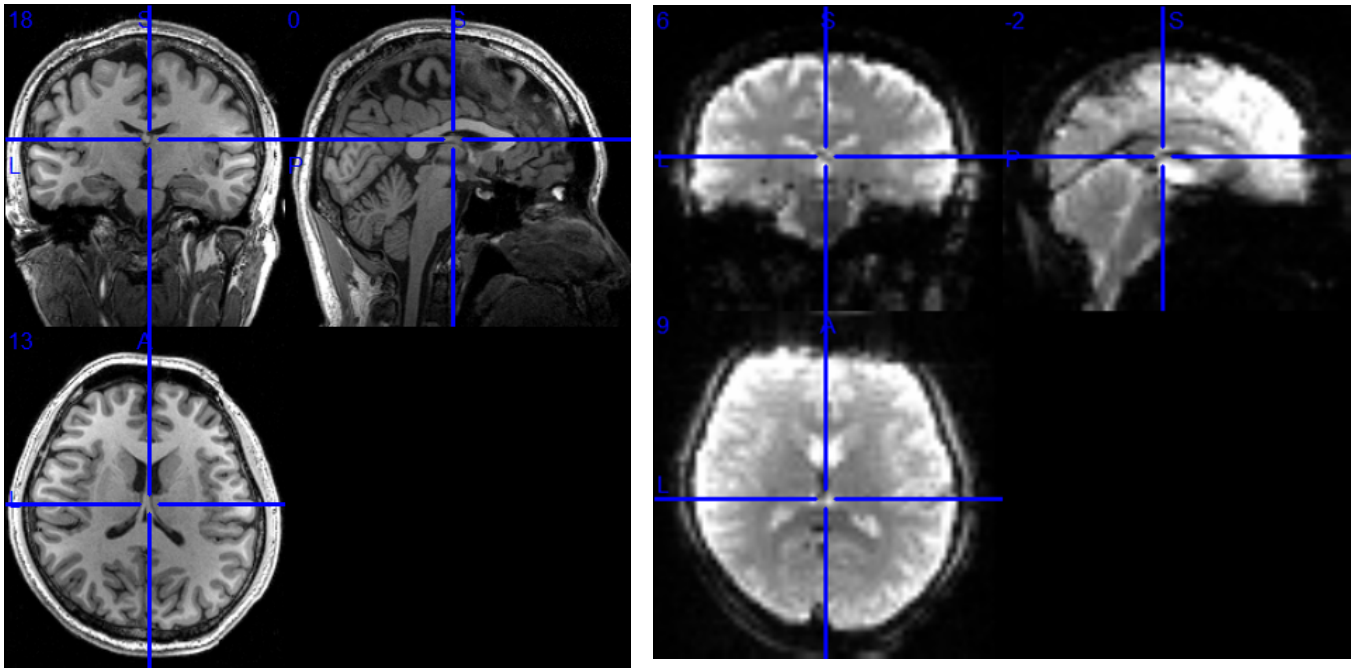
tDCS (1 mA) results – MRI T1 (left) & MRI EPI (right)
